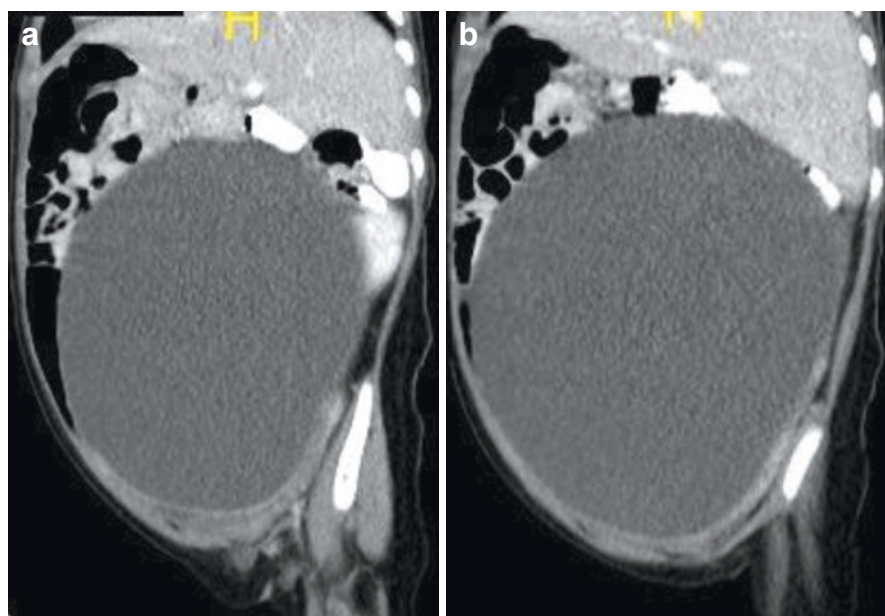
(a, b) Abdominal CT-scan showing a very large ovarian cyst filling the whole abdomen. Note also the consistency of the cyst
